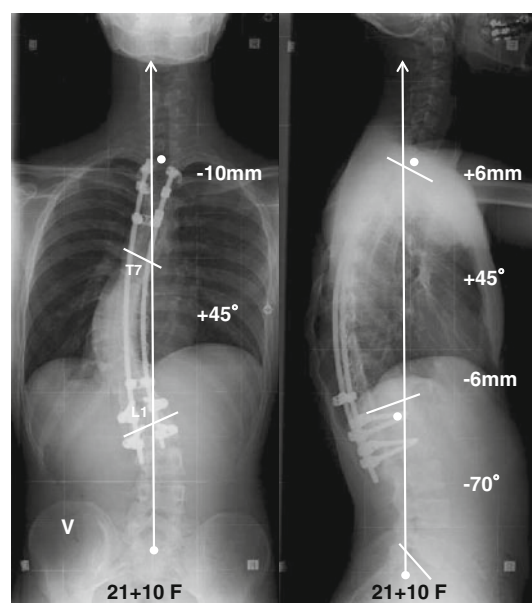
Case 1. Preoperative X-rays. The patient had left convex thoracic scoliosis with a Cobb angle of 70° between T7 and L1
